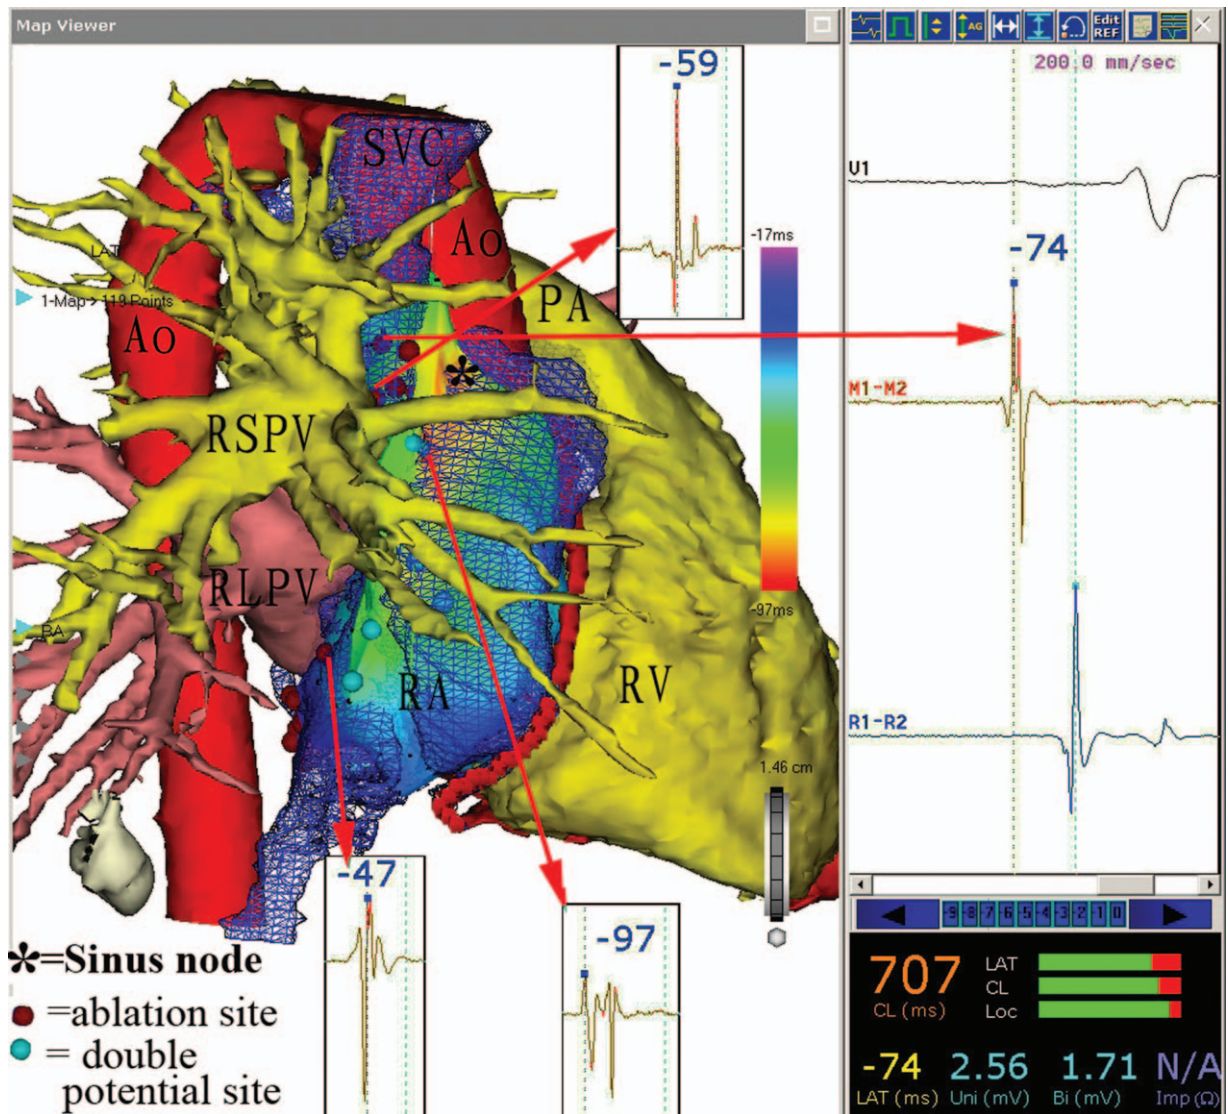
The sequence of the right atrium activation, combined with spiral CT three-dimensional imaging of the heart, showing the double potentials of the earliest stimulatory site and the high-frequency potential of the fibrillar myocardium ablation targets. The arrows show high-frequency potential. AO: Aorta; CT: Computer tomography; PA: Pulmonary artery; RA: Right atrium; RLPV: Right lower pulmonary vein; RSPV: Right upper pulmonary vein; RV: Right ventricle; SVC: Superior vena cava.
